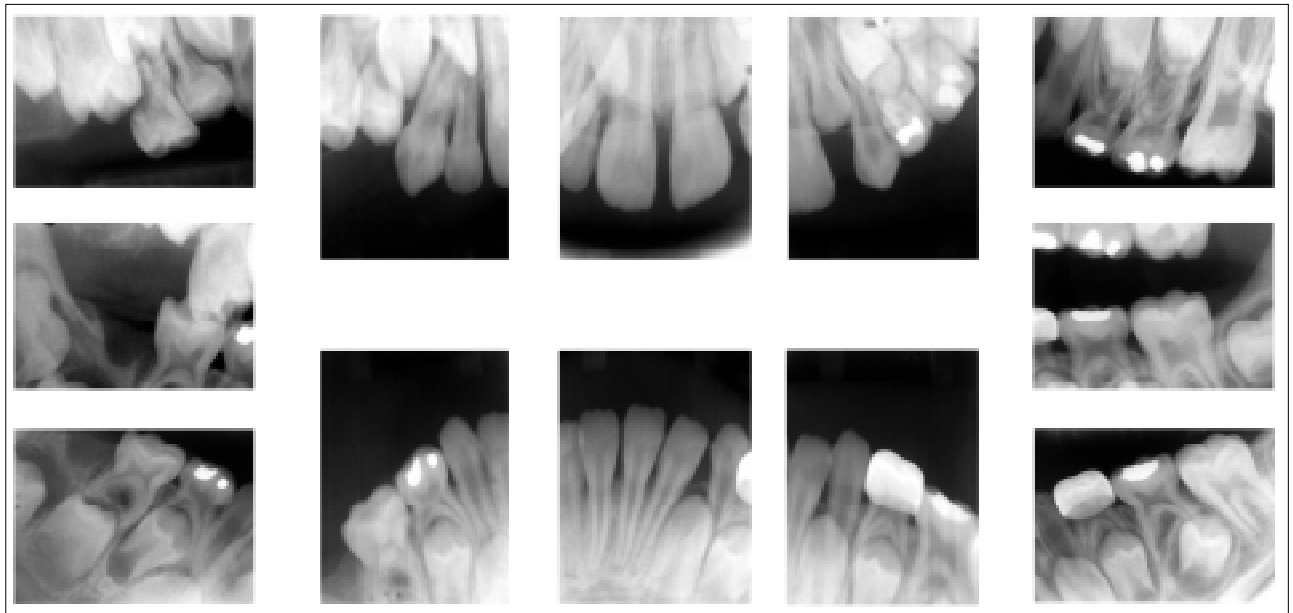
Full mouth radiographs at first visit
